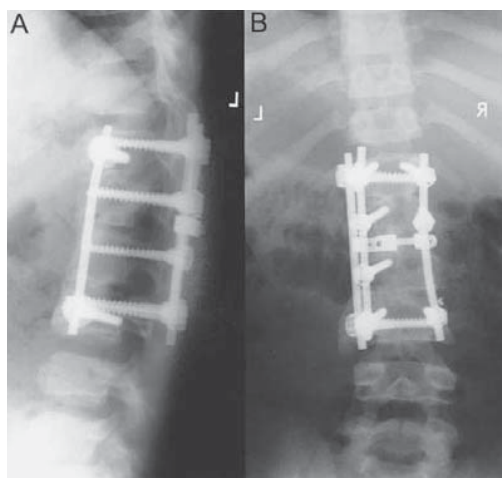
Lateral (A) and anteroposterior (B) radiographic views of the spine 1 year after the initial operative procedure confirmed a solid fusion extending from T12 to L3.
